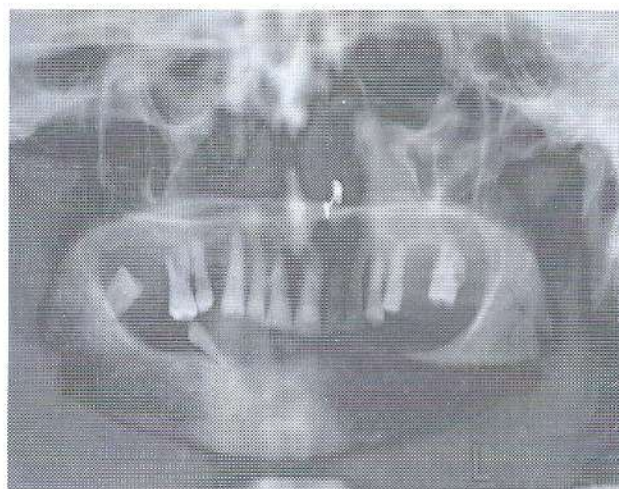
Orthopantomograph showing soft tissue counterpart of swelling occupying upper and lower jaw bones.
